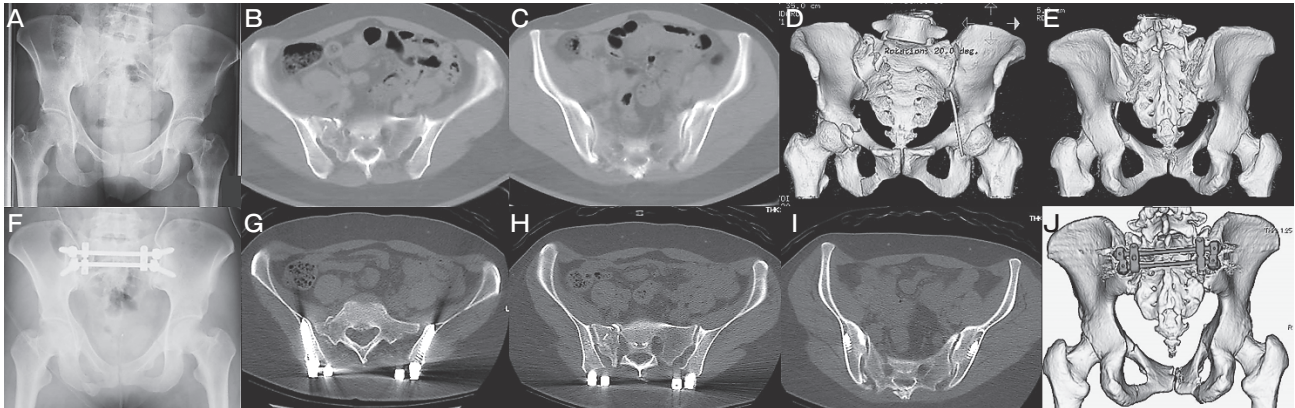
This patient was a 36-year-old woman who sustained fractures in a traffic accident. The preoperative radiograph (A), axial CT images (B, C), and three-dimensional CT images (D, E) show the right sacral, ischium, and pubis fractures. She was diagnosed with a type B2 pelvic fracture according to the AO/OTA classification system. TIF was performed in a minimally invasive manner 7 days after the injury. The postoperative radiograph (F), postoperative axial CT images (G–I), and a postoperative three-dimensional CT image (J) demonstrate the secure fixation of the left and right ilia across the fracture site.
